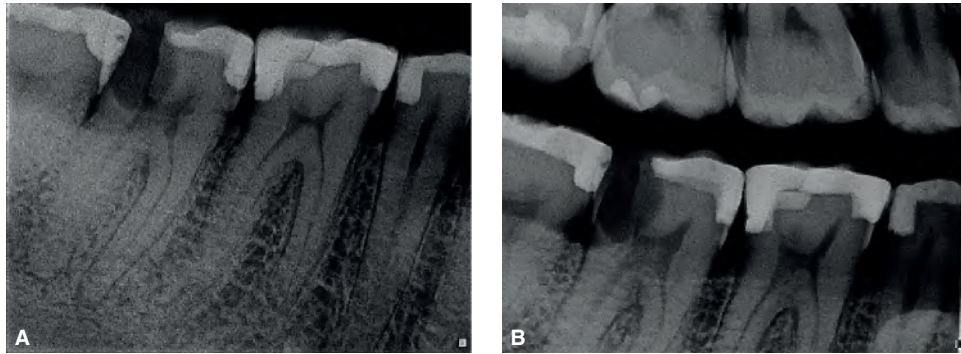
A. Periapical radiograph showing a mandibular right second molar with large coronal destruction. B. A bitewing radiograph provides a clearer image of the pulp chamber and surrounding structures. It indicates that the tooth may require crown lengthening prior to restoration. This should be factored into the patient's treatment plan.
